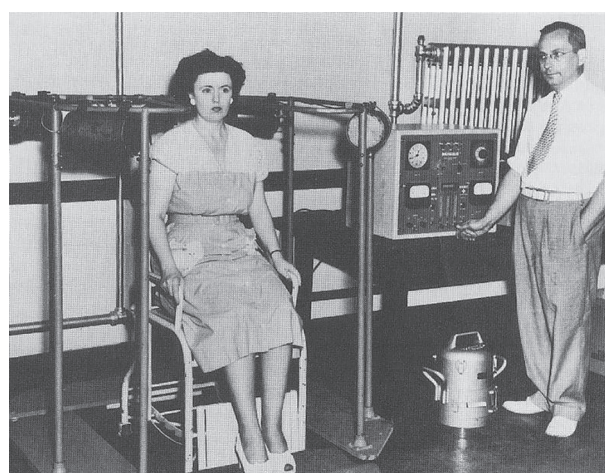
Dr. Saul Hertz (circa 1940's) Multiscaler-Uptake Testing-Dosimetry-PrecisionOncology. Courtesy: Dr. Saul Hertz Archives Greenwich, CT USA.
